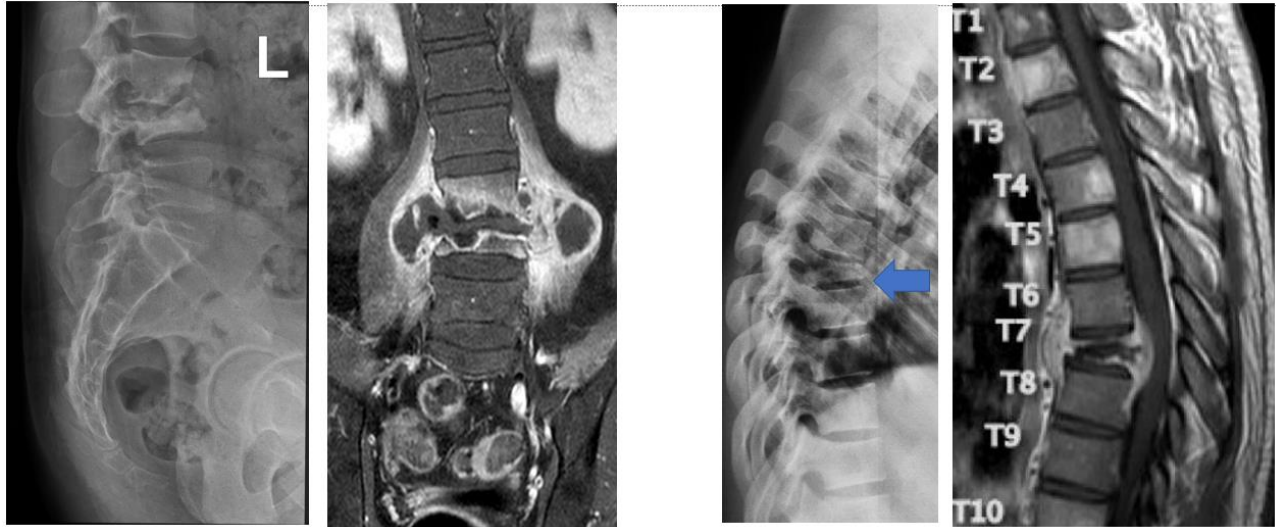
(left) Typical appearance of TB spine on plain radiographs, showing involvement of the adjoining vertebral bodies of L3 and L4 with narrowing of the intervening disc space. MRI shows the ring enhancement of the abscess. (Right) Atypical lesion of TB spine with symmetrical involvement of the vertebral body (blue arrow). MRI again shows ring enhancement to confirm TB.
